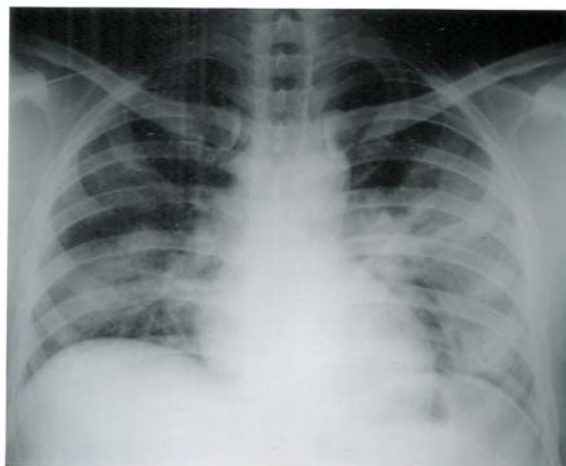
Chest radiograph showing ill-defined bilateral lower and midzone air-space opacities.
